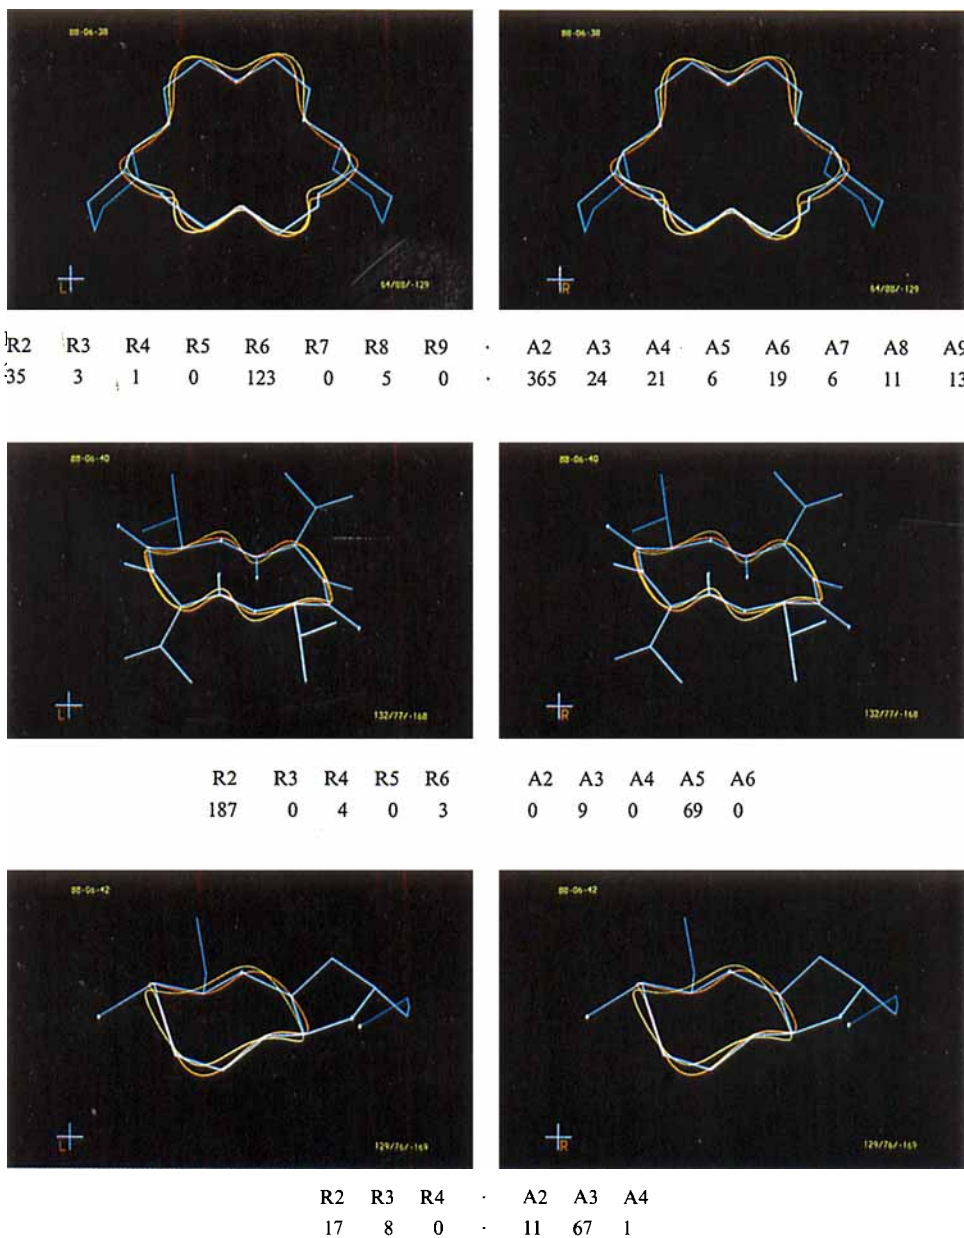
The X-ray structures of the three macrocyclic derivatives isolaurallene (9-membered ring, bottom) [9], cyclic depsipeptide (12-membered ring, middle) [10], 18-crown-6 derivative (18-membered ring, top) [1], displayed together with continuous representations of the corresponding Fourier series, using either all terms (red) or only the largest axial component and largest radial component (yellow). Relative intensities of the axial and radial Fourier components, A_n and R_n ($n = 2, 3, \dots, N/2$), respectively, are given below.
